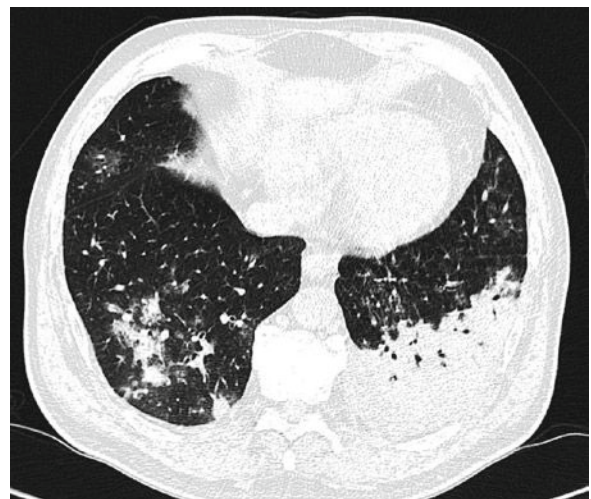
Chest CT showing alveolar infiltrates and nodule in a neutropenic patient with invasive fusariosis
